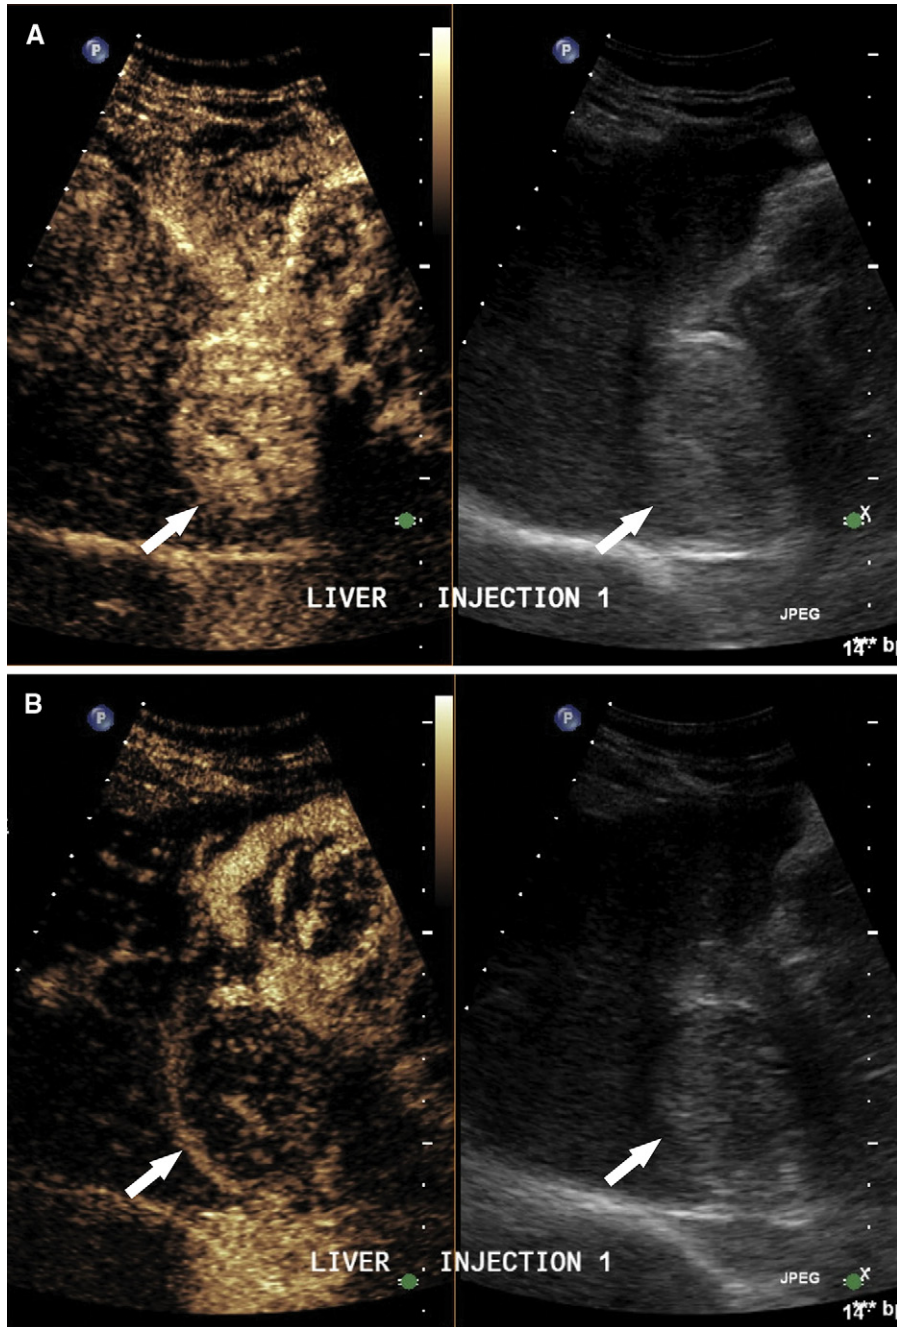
Contrast enhanced ultrasound of a 59-year-old man with hepatocellular carcinoma (HCC). (A) Sagittal contrast-enhanced of a liver mass, demonstrating enhancement during the arterial phase of the study (arrows). (B) This mass exhibits the characteristic washout on the portal venous phases, consistent with HCC (arrows).
